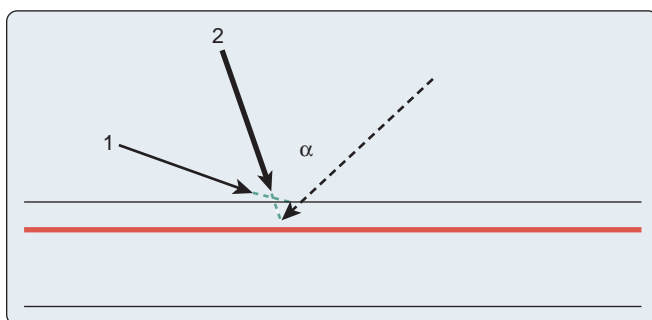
Demonstration of the “triangulation” technique typically applied with ultrasound-guided (UG) venous and/or arterial cannulation in the transverse imaging approach. The echo imaging plane and the needle plane can be viewed as the two sides of a triangle that should meet and intersect at the depth of the structure (eg, radial artery [red line]) for which cannulation is attempted. The experienced operator will change the angle (α) between the two planes (ultrasound and needle) and the distance (needle insertion site vs imaging plane), depending on the depth of the structure. To follow the needle tip in the transverse approach (vessel viewed in short axis), the echo plane or needle insertion angle has to be further adjusted from needle entry through the skin to the perforation of the vessel. A greater angle is used (echo plane angled toward the skin [1]) to visualize the needle tip after it penetrates the skin, and then a more perpendicular angle relative to the skin is applied to see the needle tip entering the vessel lumen (2).
